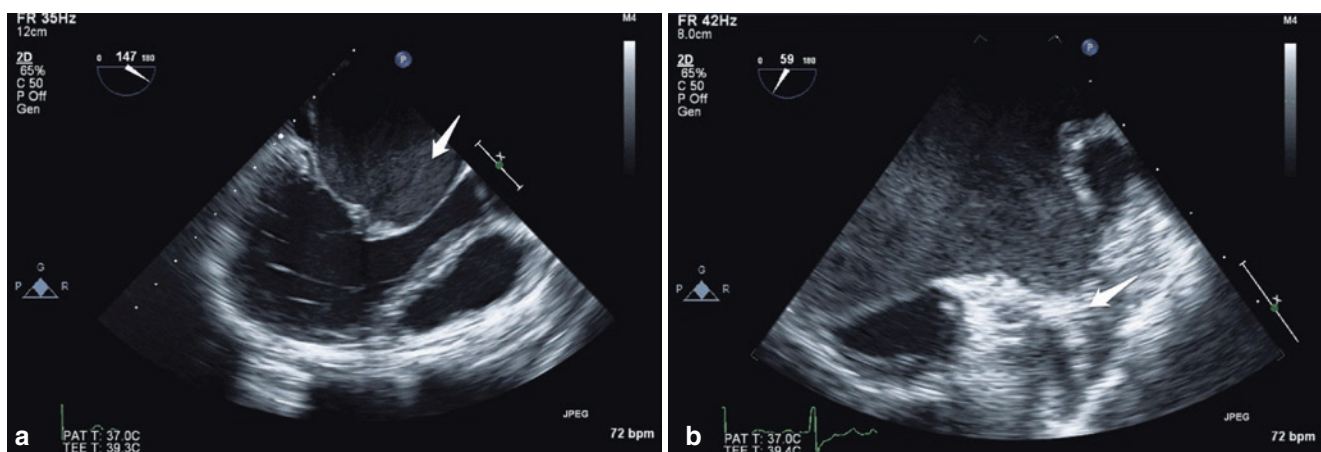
On this image, taken during a transesophageal echocardiogram of a patient with severe mitral stenosis, there is significant spontaneous contrast noted in the left atrium (arrow, a). The patient also had a left atrial appendage thrombus (arrow, b)
